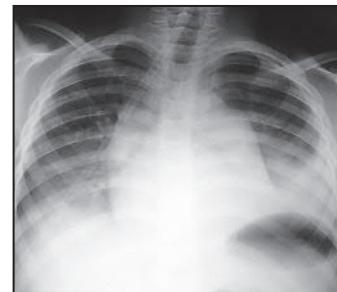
Chest X-ray in acute sickle chest syndrome showing bilateral lower zone consolidation. (Courtesy of Parviz Habibi.)
